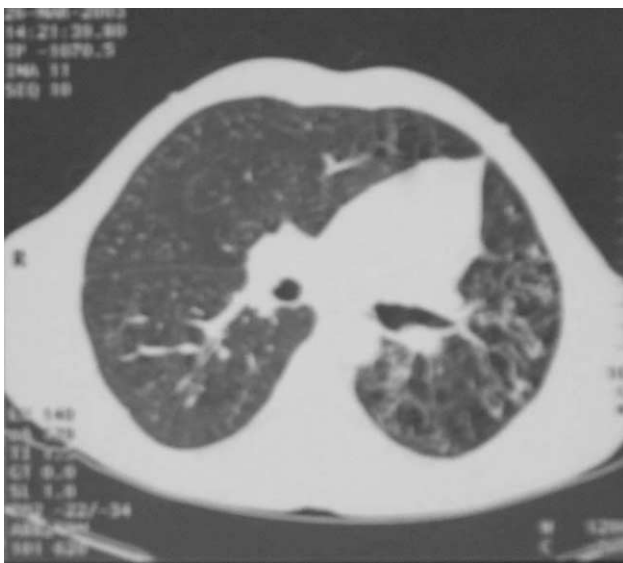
HRCT scan showing bronchiectasis.
